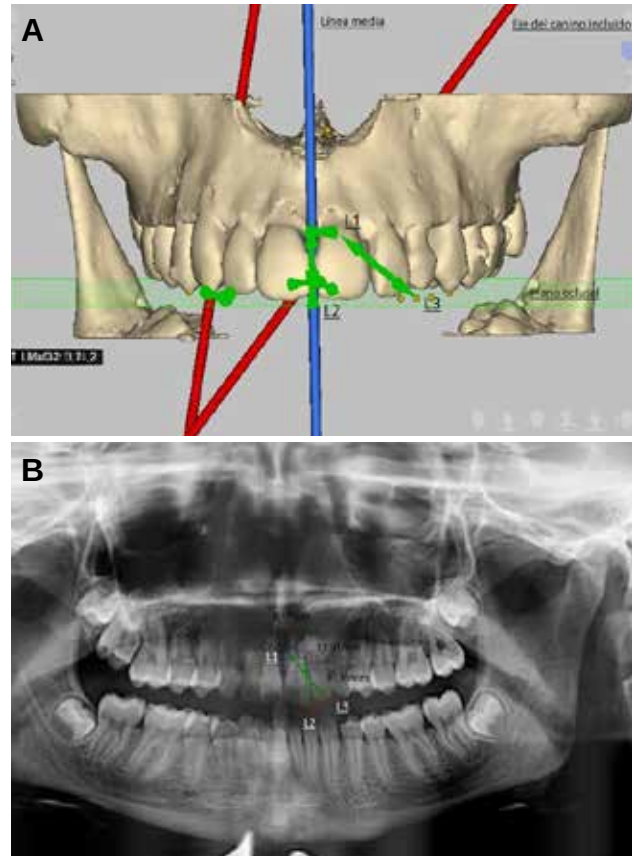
Reference lines in CBCT.
